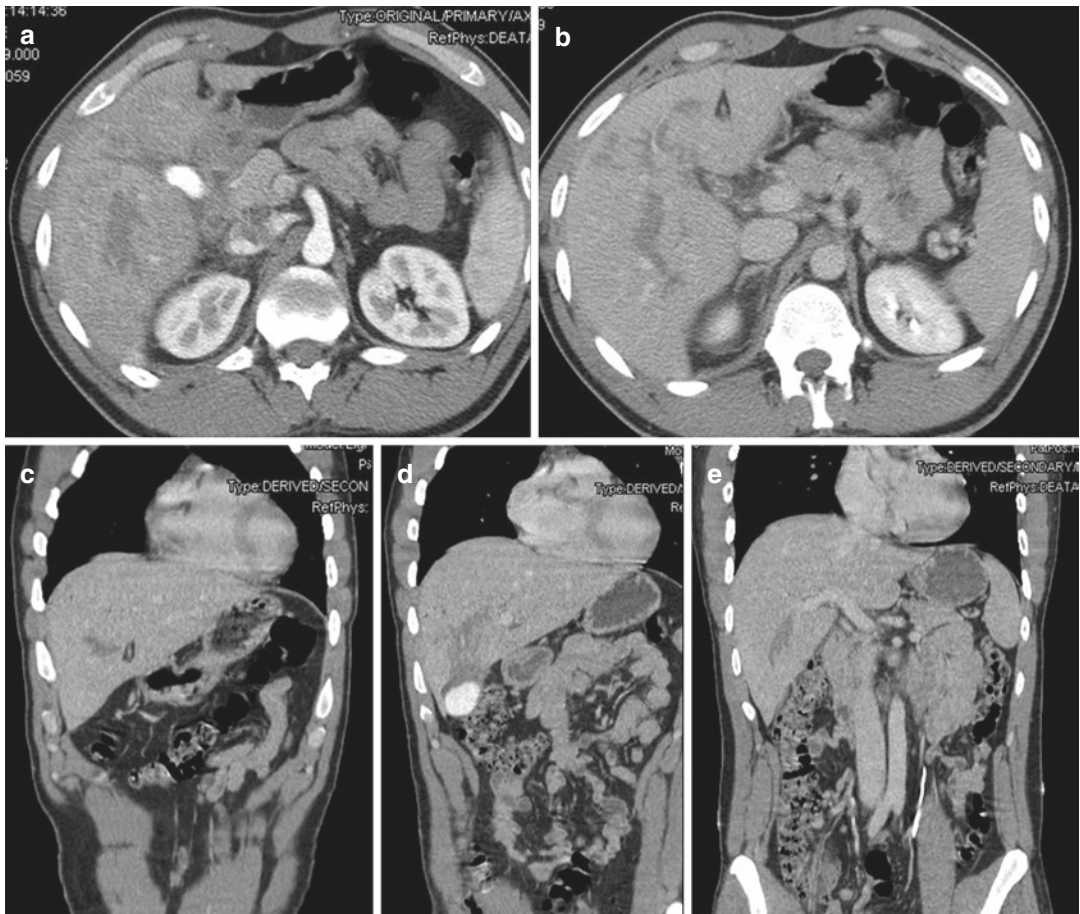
Contrast-enhanced CT (a–e) confirms the size of the injuries depicted by CEUS
